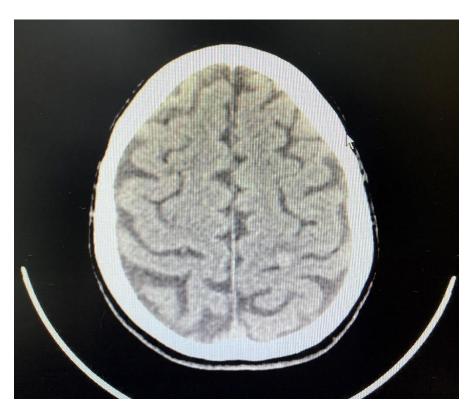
Brain CT revealing reduction in the size of the perilesional edema after intravenous corticosteroid treatment
